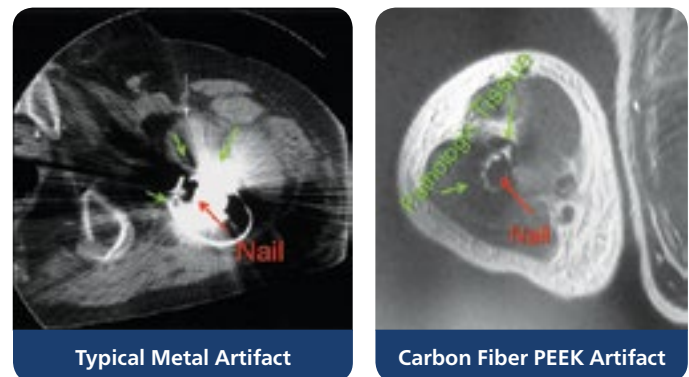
Radiolucency: Improved visualization with CT and MRI.*
